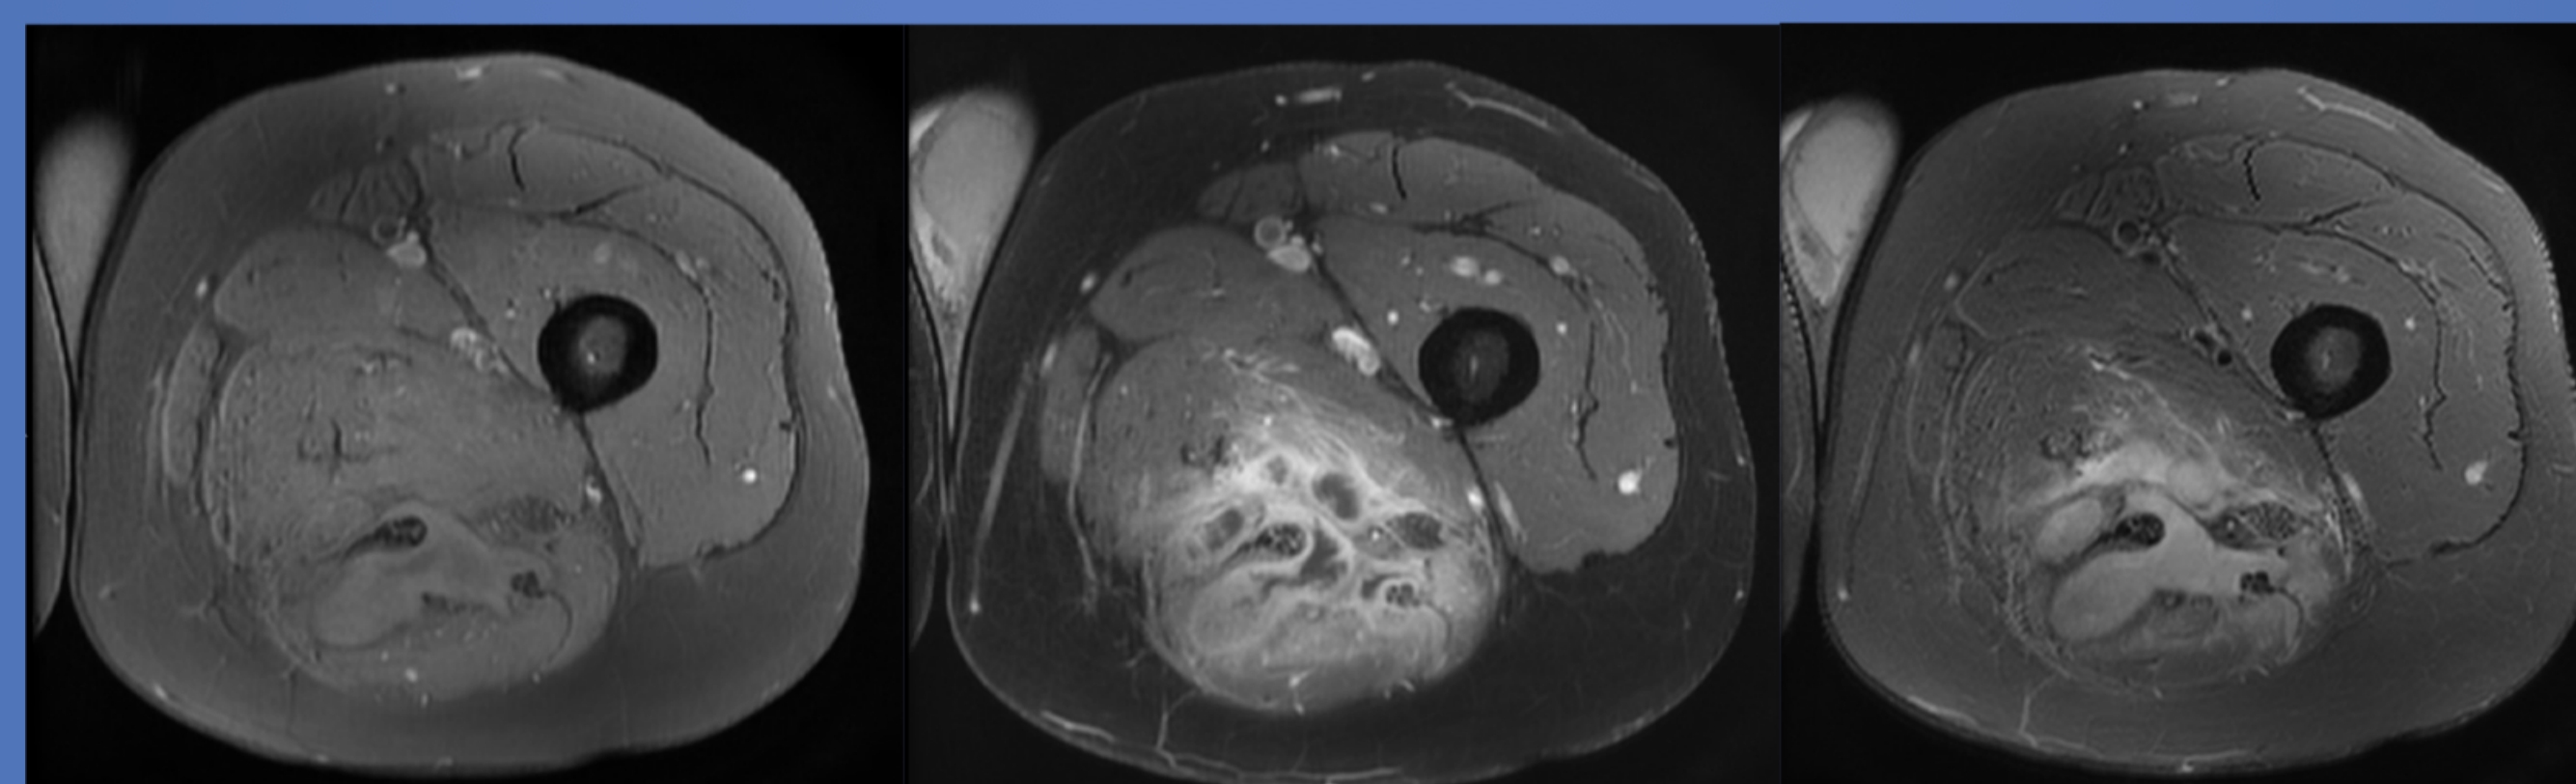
Magnetic resonance imaging of the left thigh reveals heterogeneous signal intensities on T1-weighted sequences both pre-contrast (left) and post-contrast (middle). The T2-weighted sequence (right) reveals circumferential enhancement with relative homogeneity of the mass. A necrotic core is visible and the margins are ill-defined. Marked peri-lesional enhancement indicates invasion and edema disproportionate to the size of the lesion. These findings favor neoplasm over infection[33-35].
